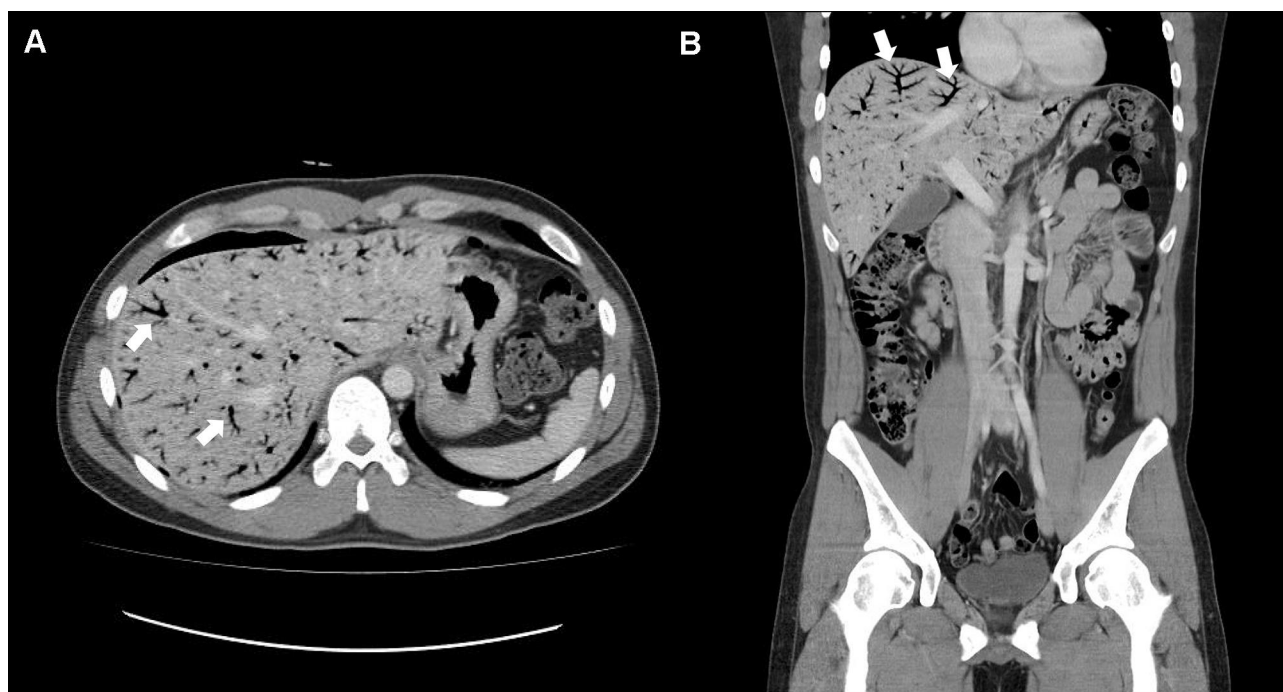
Contrast-enhanced computed tomography showing extensive portal venous gas of the entire liver (white arrow). Axial (A) and coronal (B) view.
